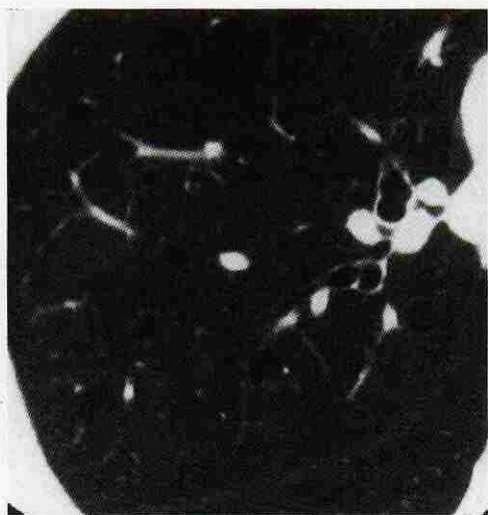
Computed tomogram of patient with lymphangioleiomyomatosis. Note pencil-thin smooth walls of multiple cystic lesions. The cysts were distributed homogeneously throughout the upper and lower lobes, characteristic of lymphangioleiomyomatosis.
